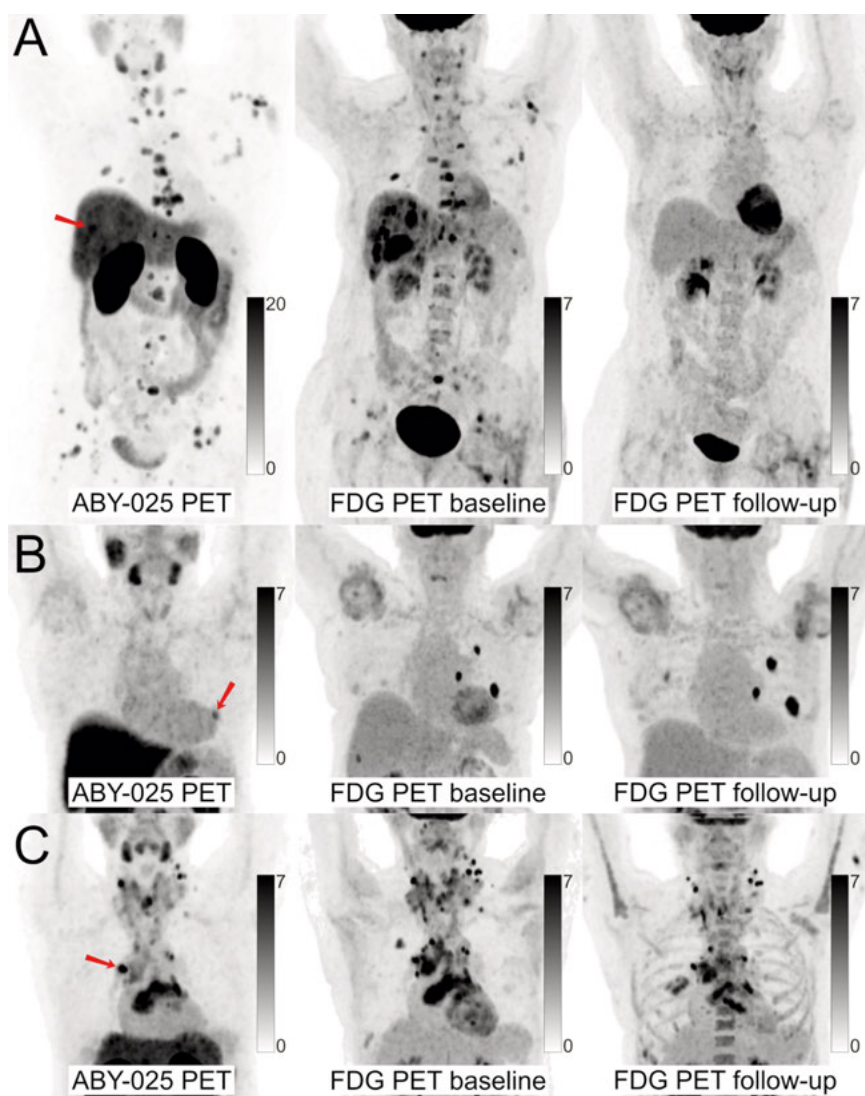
^{68}Ga -ABY-025 PET/CT and ^{18}F -FDG PET/CT images at baseline with ^{18}F -FDG PET/CT follow-up after 2 cycles of treatment in biopsy-confirmed HER2-positive disease. (A) Patient with high ^{68}Ga -ABY-025 uptake (SUVmax, 21), previously received 3 lines of treatment. ^{18}F -FDG PET/CT follow-up showed complete metabolic response. (B) Patient with low uptake (SUVmax, 5.4), who previously received 3 lines of treatment. ^{18}F -FDG PET/CT follow-up showed disease progression (Δ -TLG, 168%) despite HER2-targeted treatment. (C) Patient with heterogeneous ^{68}Ga -ABY-025 uptake, who previously received 7 lines of treatment. ^{18}F -FDG PET/CT follow-up showed a heterogeneous response, with lesions higher in ^{68}Ga -ABY-025 uptake tending to have a better response. Arrows indicate biopsy sites.
